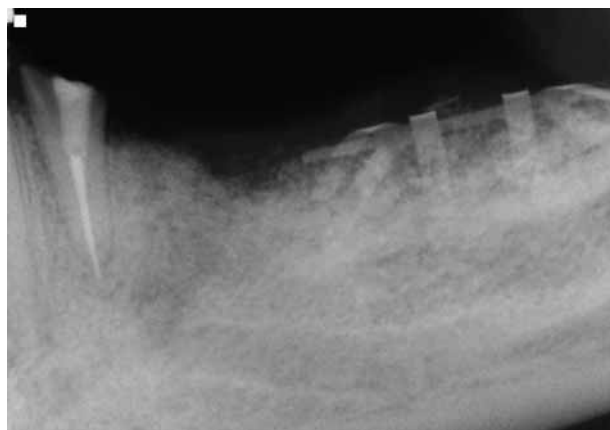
The radiographs here and in Fig. 3 show a case where the mandibular left first premolar could perhaps be retained, but it may be better to extract and use the site for an implant. This allows the lower left quadrant to be restored with an implant-supported fixed partial denture. By using the first premolar site for implant placement, the surgeon can avoid the mental foramen in the second premolar area.
